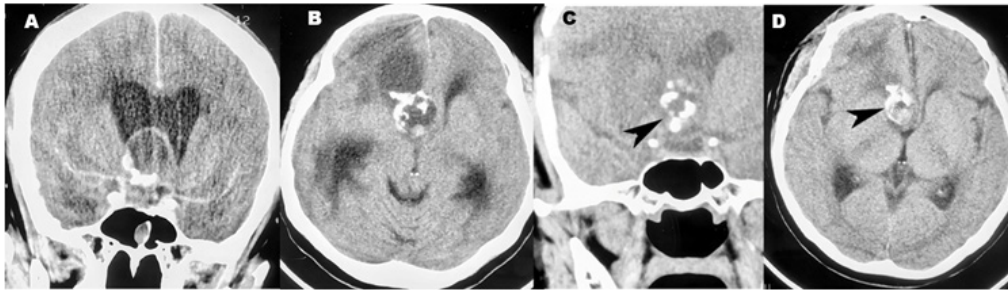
A preoperative enhanced coronal CT scan (A) and axial CT scan (B) CT scans revealed a calcified tumour in the anterior third ventricle with obstructive hydrocephalus. An initial postoperative coronal (C) and axial (D) CT scans showed a revealed partial tumour removal through a right frenotomy. The arrowhead pointing indicates the tumour.
